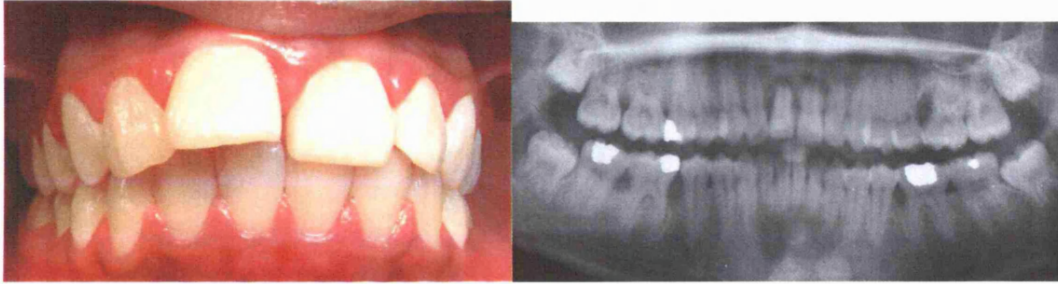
Frontal intraoral picture and orthopantomograph of the 14-year old Black- Caribbean female patient described in paragraph 8.4.2. Localised vertical bone defects are present around all first molars and 11 (UR1). A diagnosis of LAgP was made.
